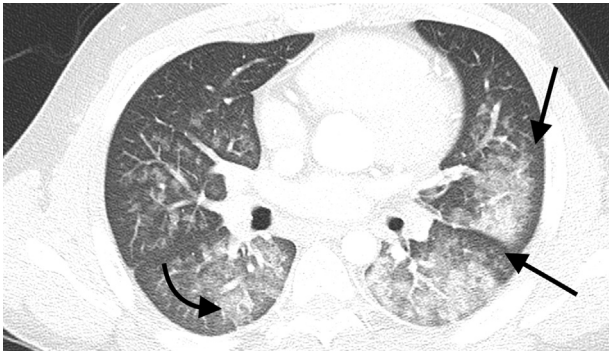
Cocaine hemorrhage. Axial CT in lung window in a patient with recent cocaine abuse shows pulmonary hemorrhage and centrilobular ground-glass attenuation (curved arrow). Note the subpleural sparing (straight arrows), which is a hallmark of pulmonary hemorrhage.
